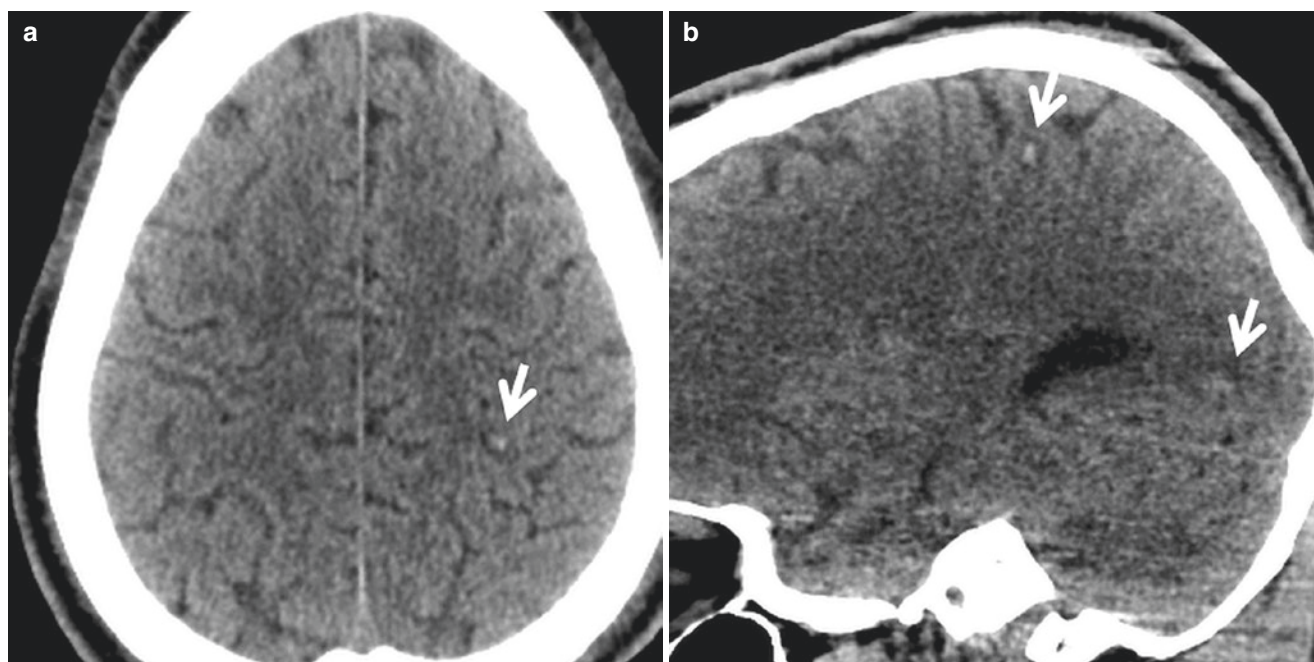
Subtle intracranial hemorrhage in NCCT for patients with stroke alert. (a and b), Axial and sagittal CT demonstrate a small focus on intraparenchymal hemorrhage in the left parietal lobe (*arrow*). An additional focus of hemorrhage is seen in the left occipital lobe on the sagittal image (*arrow*). (c and d), Axial and coronal CT show sulcal
